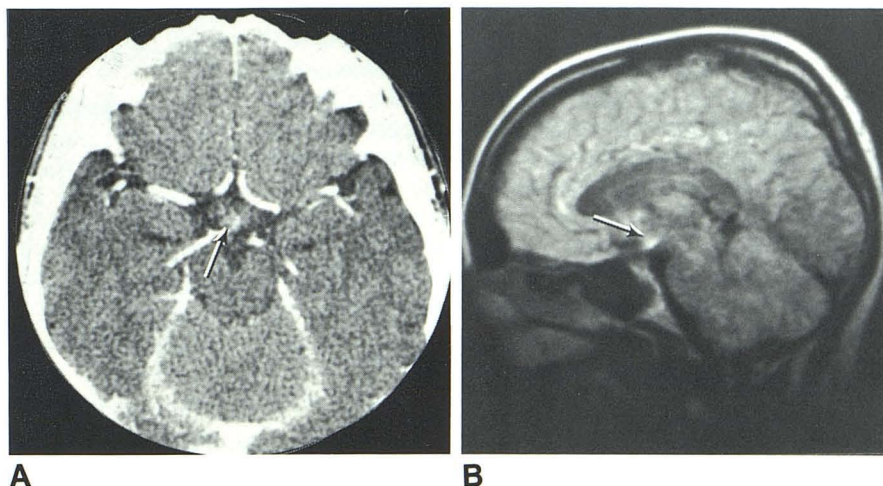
Case 2. A, Contrast-enhanced coronal CT scan shows region of abnormal contrast enhancement (arrow) in pituitary fossa. Sagittal (B) and transverse (C) MR images (SE 1580/80) demonstrate large suprasellar lesion involving hypothalamus extensively.
